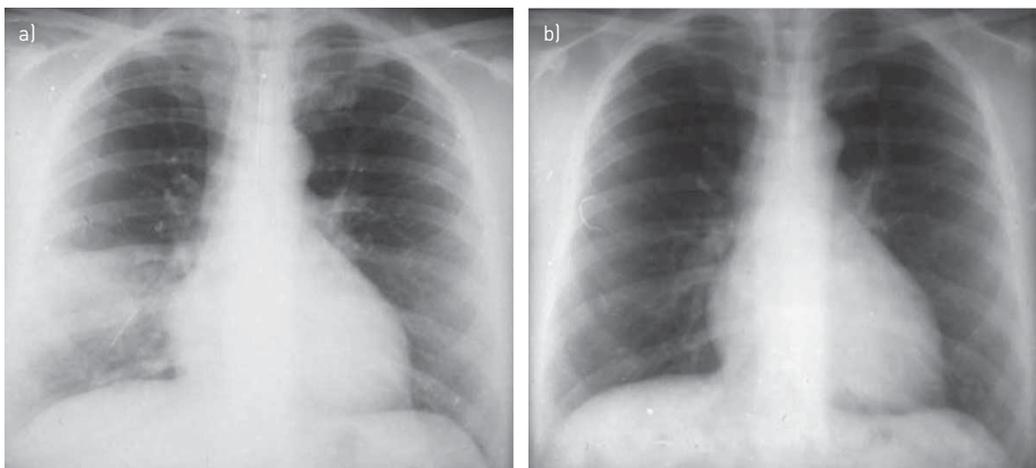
Chest radiograph showing a transient segmental infiltrate in the right middle lobe a) directly following BAL and b) 24 h after BAL.
